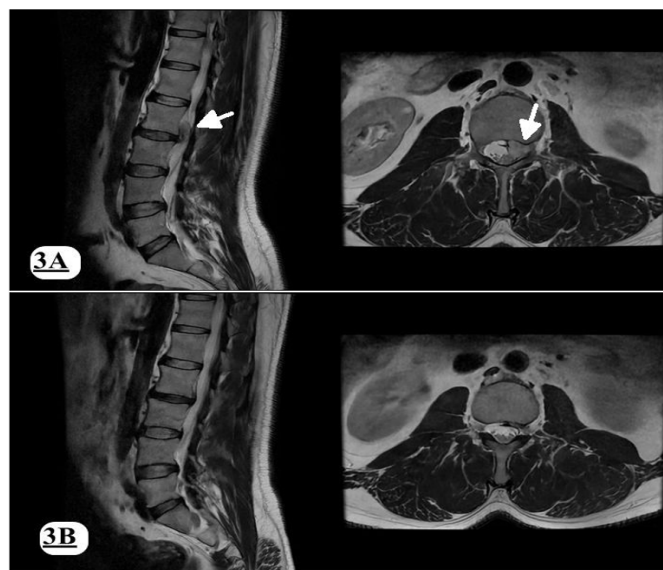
T2-weighted MR images of a 42-year-old man showed an extruded and upward migrated disc herniation at the L2-3 level, and it was located in the left lateral recess with severe compression of the left L3 nerve root. The herniated part was observed as soft and edematous (indicated with white arrow) (3A). Control T2-weighted MR images of the patient examined nine months later showed that the herniated disc had disappeared completely, and the left nerve root was free throughout its foramen (3B).
